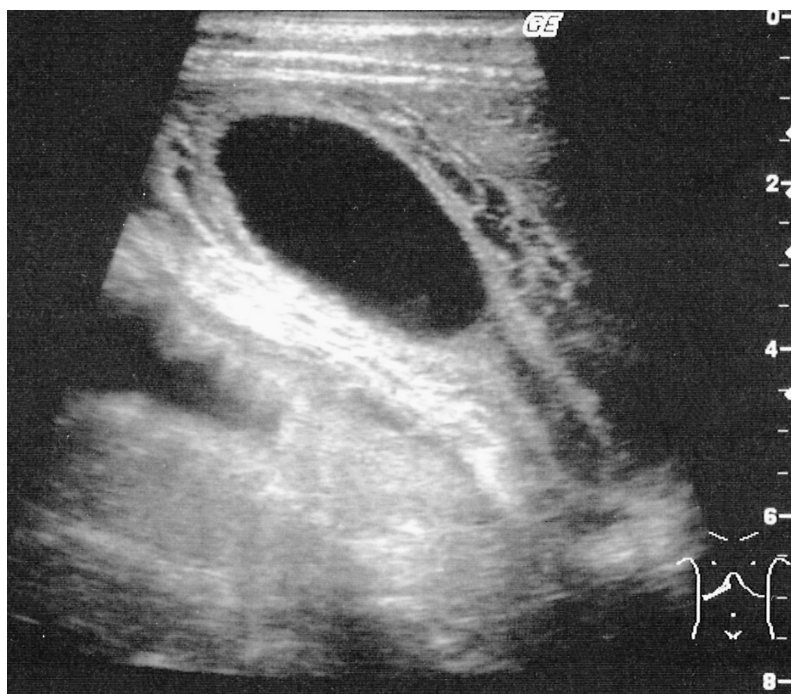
Ultrasonography of the abdomen showing atypical thickening of the gallbladder wall and fluid collection around the gallbladder
